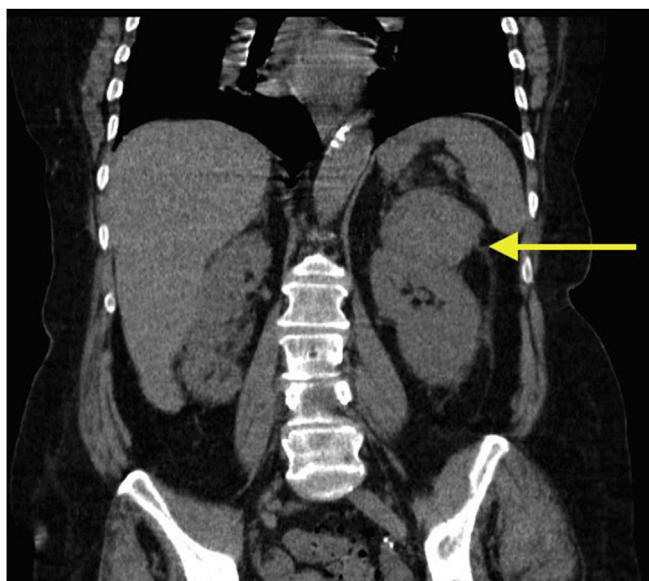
Coronal section of a computed tomography (CT) abdomen and pelvis scan depicting a left kidney upper pole mass measuring $72 \times 60 \times 51$ mm (indicated by the yellow arrow). Appearances are suggestive of a possible renal cell carcinoma. (For interpretation of the references to colour in this figure legend, the reader is referred to the Web version of this article.)
